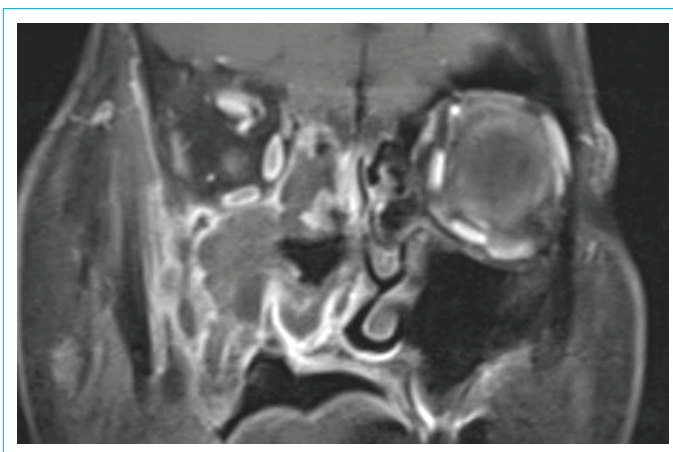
Turbo-spin echo (TSE) with fat saturation (FS) for coronal T1-weighted MRI of the cranium revealed heterogeneous contrast-enhancing lesion in the right maxillary and ethmoidal sinuses.
